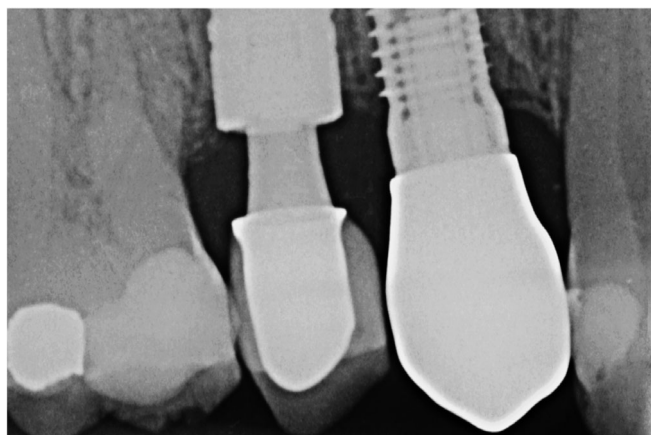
Radiographic image of the emergence profile design for a tissue-level restoration on a maxillary right first premolar implant. The polished collar replaces the C zone
